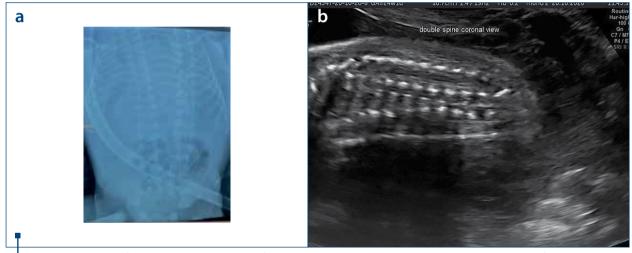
a) X-ray of the newborn's spines that fuses in the sacral region; b) sonographic coronal view of the spine
